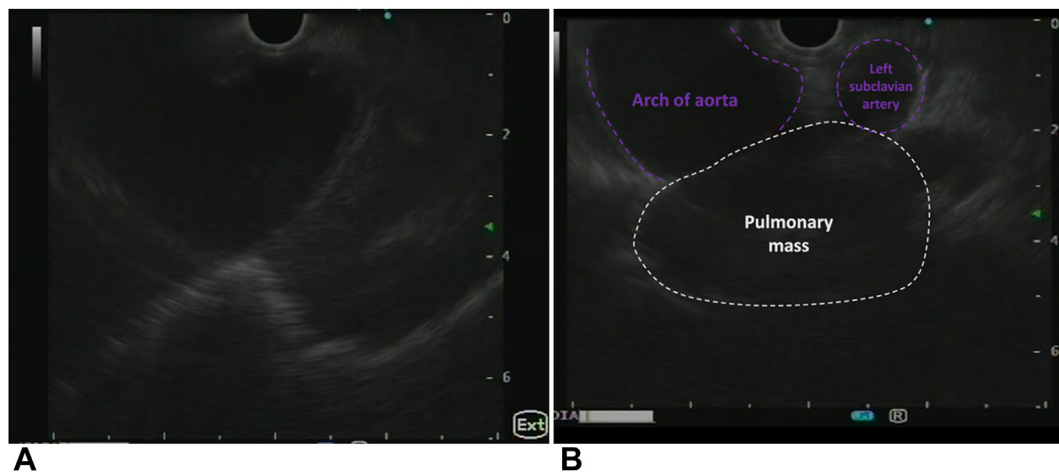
A and B, EUS transesophageal evaluation of the pulmonary mass, which is behind the arch of the aorta, next to the origin of the left subclavian artery.
